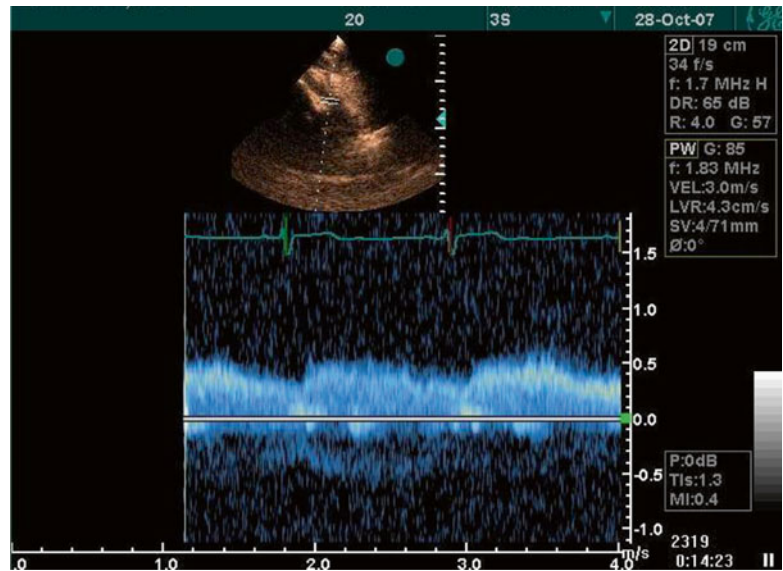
Doppler flow study of the abdominal aorta demonstrating decreased pulsatility and absence of early diastolic flow reversal in the significant CoA
